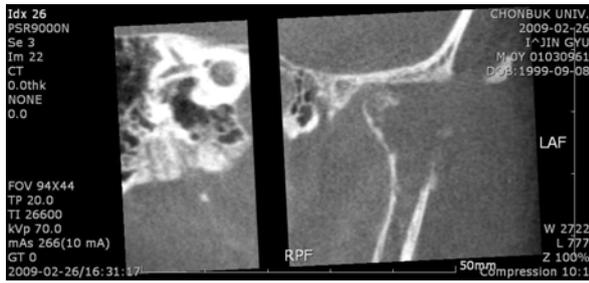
Coronal view of left mandibular condyle by cone beam CT.
